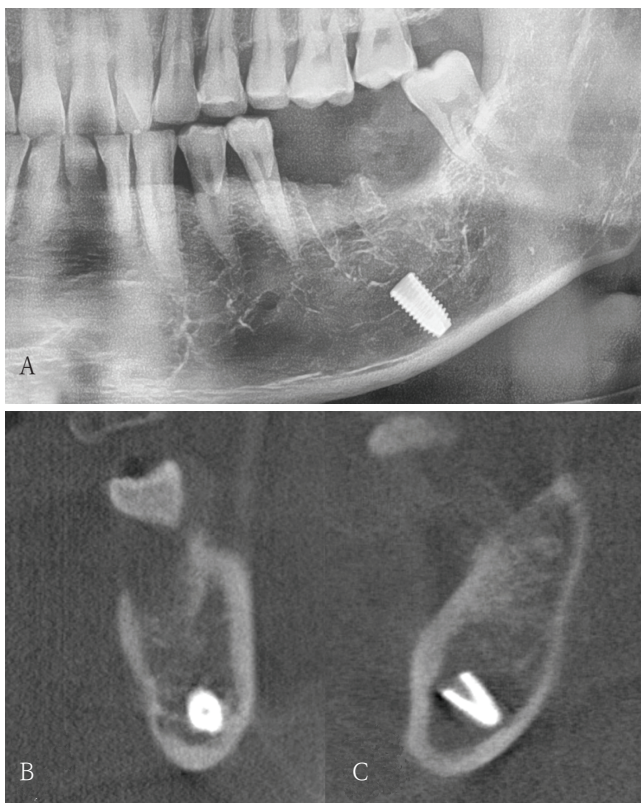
A. Panoramic radiograph shows a displaced implant fixture in the left mandibular first molar region. Coronal (B) and sagittal (C) cone-beam computed tomography images reveal the fixture located near the inferior border of the mandible. An ill-defined radiolucent area with decreased trabecular bone pattern and no cortical expansion is observed at the displacement site
